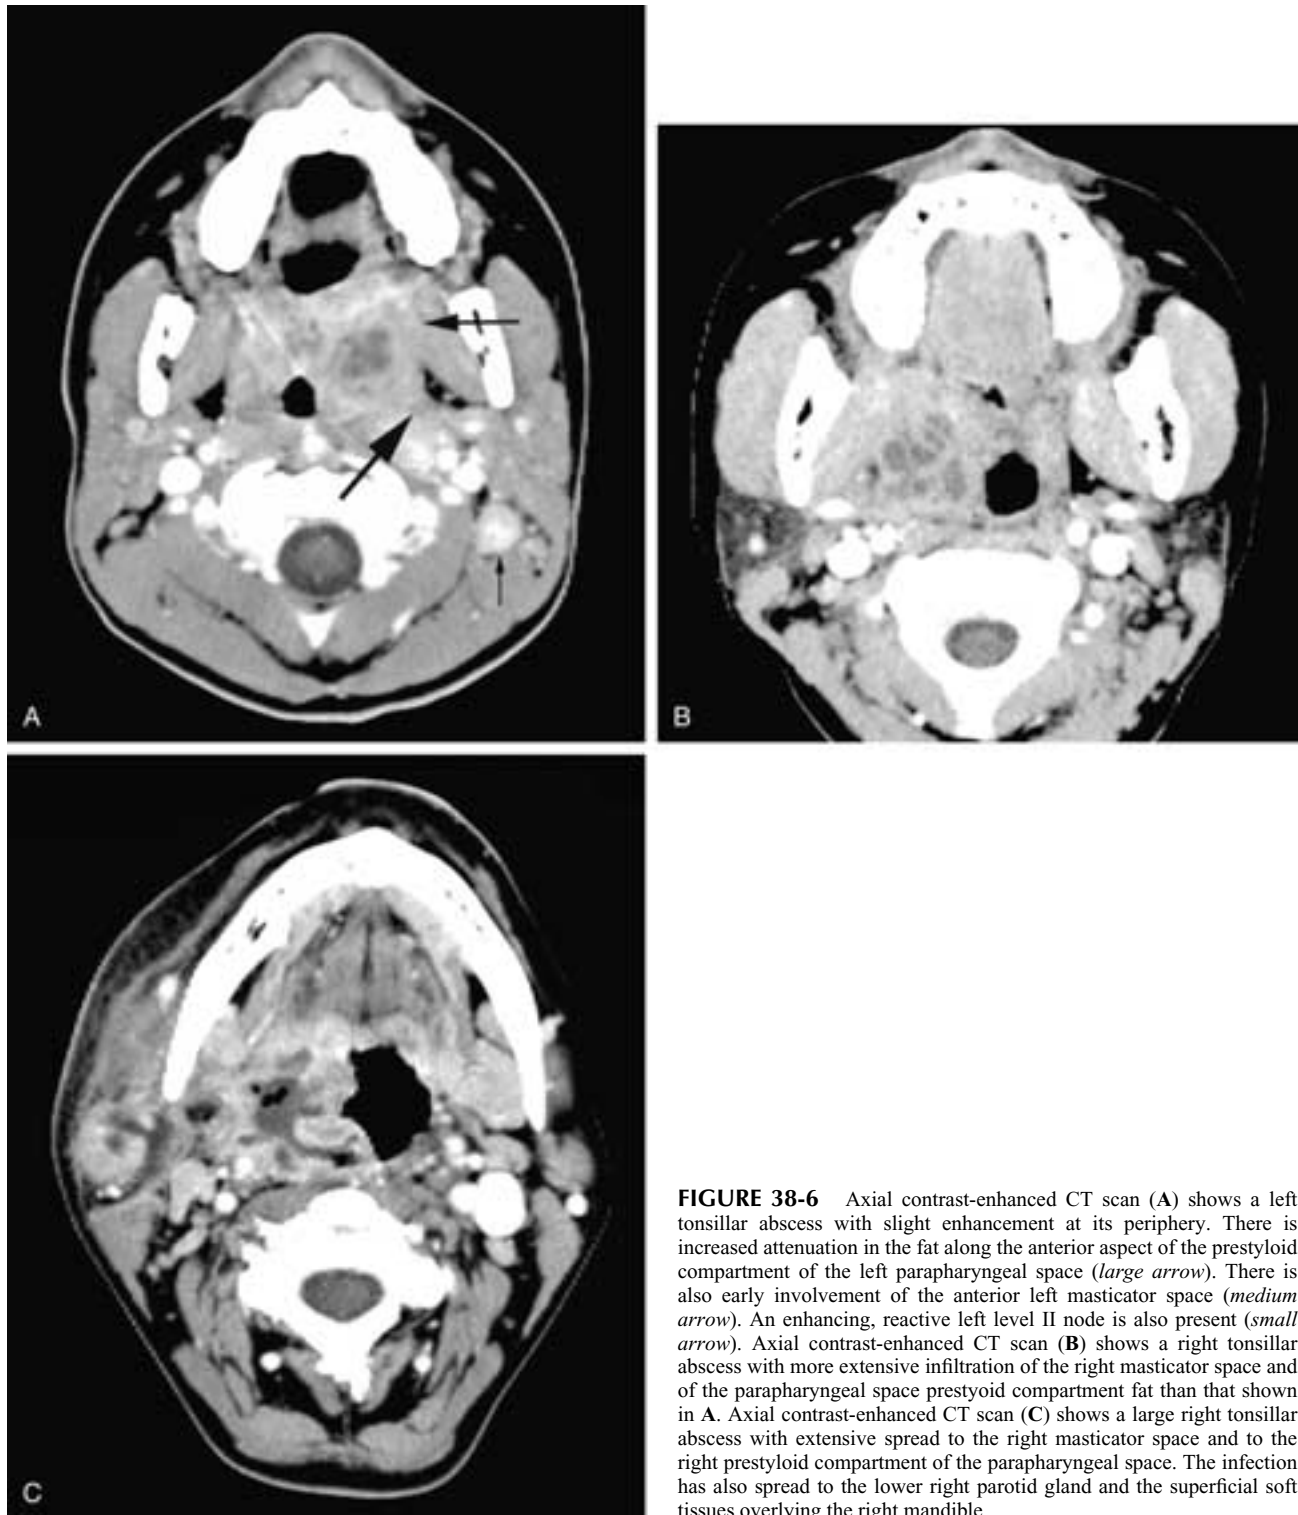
Axial contrast-enhanced CT scan (A) shows a left tonsillar abscess with slight enhancement at its periphery. There is increased attenuation in the fat along the anterior aspect of the prestyloid compartment of the left parapharyngeal space (*large arrow*). There is also early involvement of the anterior left masticator space (*medium arrow*). An enhancing, reactive left level II node is also present (*small arrow*). Axial contrast-enhanced CT scan (B) shows a right tonsillar abscess with more extensive infiltration of the right masticator space and of the parapharyngeal space prestyloid compartment fat than that shown in A. Axial contrast-enhanced CT scan (C) shows a large right tonsillar abscess with extensive spread to the right masticator space and to the right prestyloid compartment of the parapharyngeal space. The infection has also spread to the lower right parotid gland and the superficial soft tissues overlying the right mandible.
